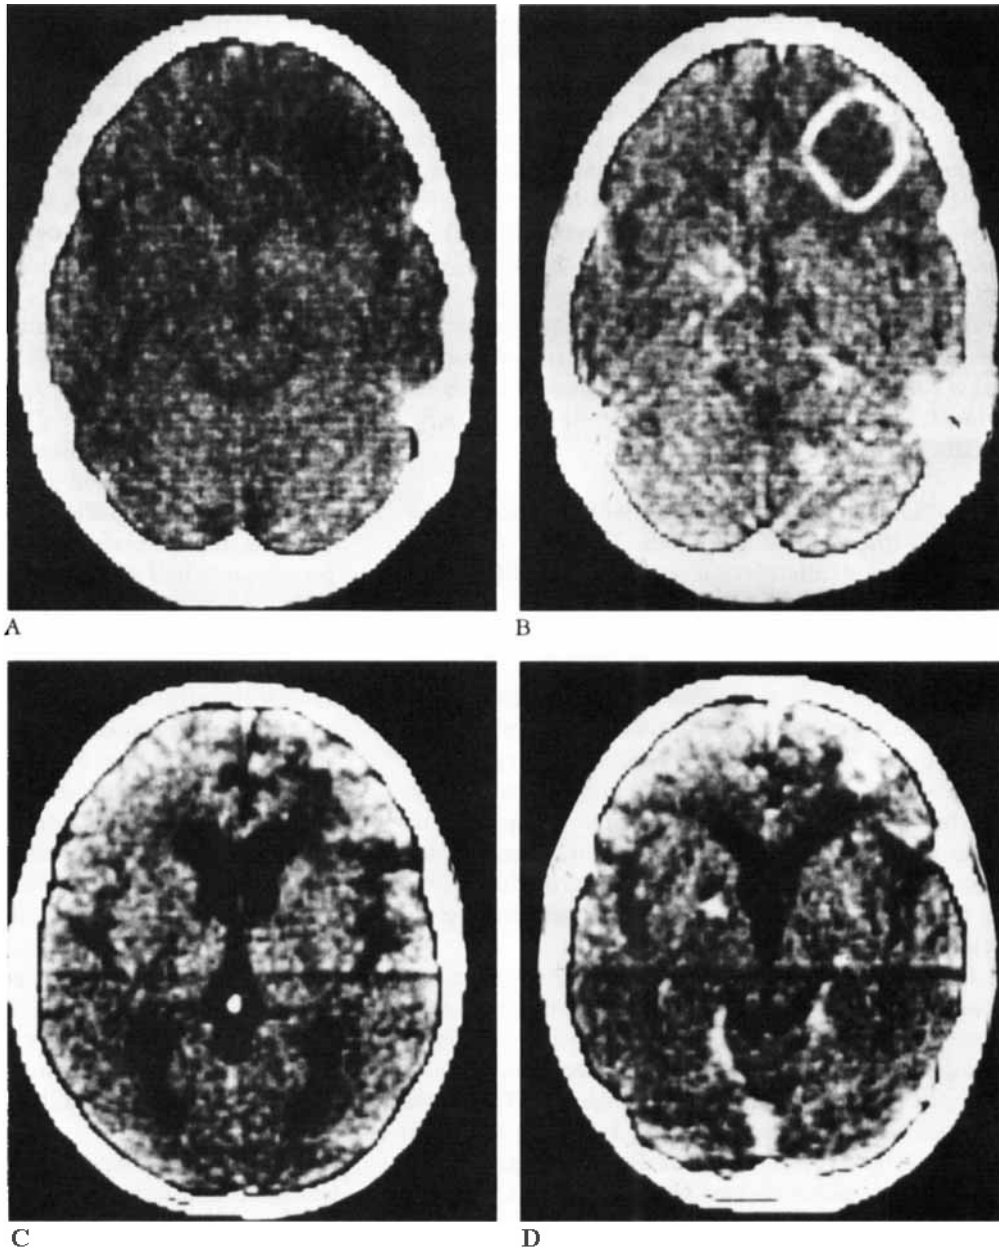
CT appearance of a *Toxoplasma gondii* brain abscess. The preinfusion scan (A) shows a low-density region in the right frontal lobe, which demonstrates characteristic ring enhancement after intravenous contrast infusion (B). In addition, two smaller contrast-enhancing lesions are seen in the left basal ganglia and right cerebellar hemisphere (B). Eight months after treatment with sulfadiazine and pyrimethamine the noncontrast scan (C) shows only a small low-density area in the right frontal lobe and a smaller ring of enhancement (D) after contrast infusion.
